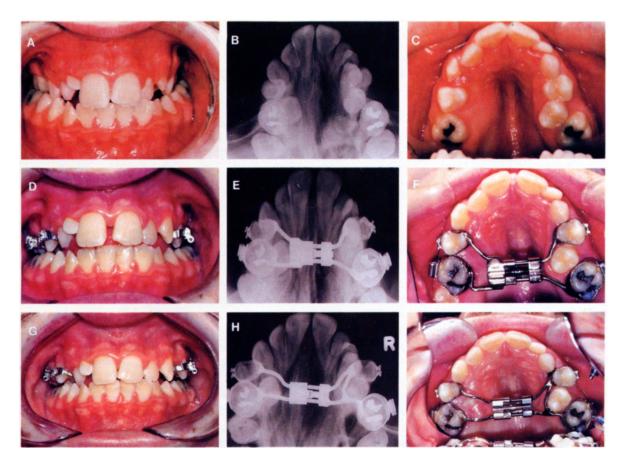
Frontal, occlusal radiograph and occlusal views before (A through C), during (D through F), and after (G through I) rapid maxillary expansion.
